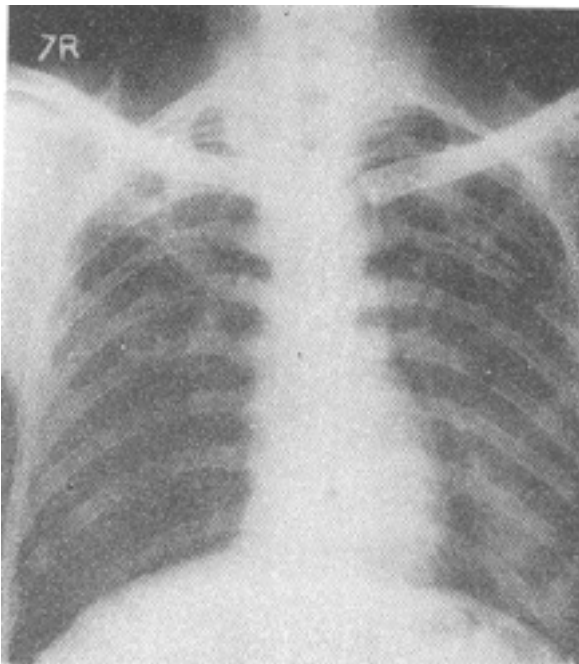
Chest radiograph on presentation showing bilateral fibrocavitary disease along with infiltrative lesions in left lower /one
